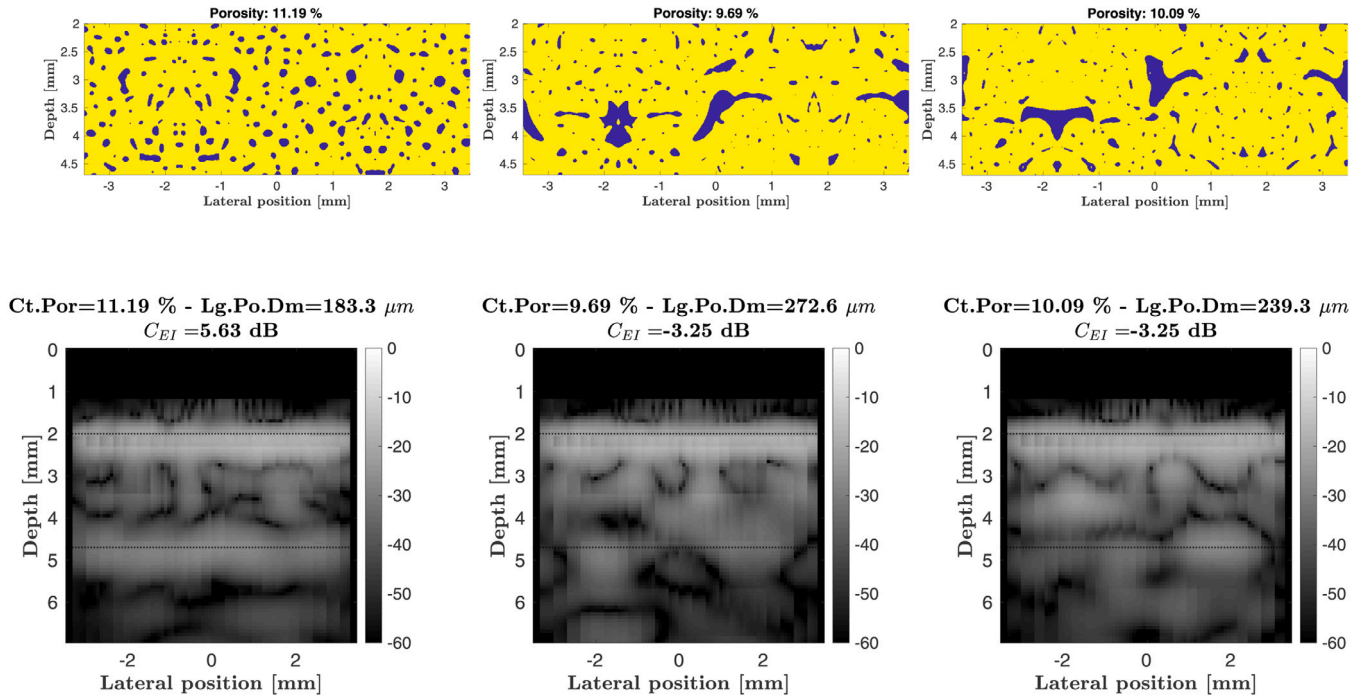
Binarized SR- μ CT image of microstructure with similar porosities (top) but increasing large pore size and their corresponding reconstructed ultrasound images (down).
